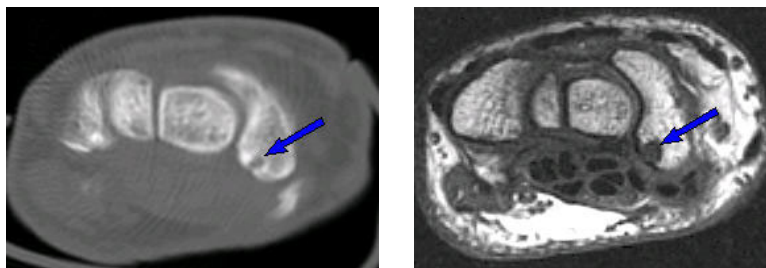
Bone erosion in scaphoid (blue arrows) is apparently larger as depicted by the low signal focus on T1 SE image (right), as compared to CT (left).
